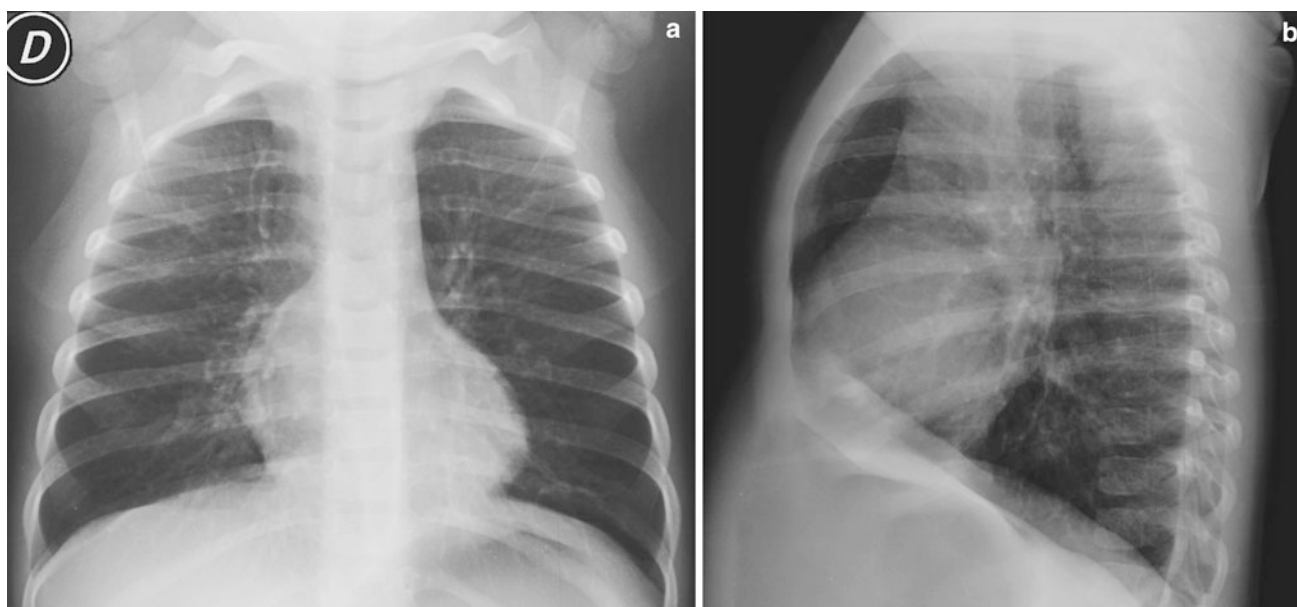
Frontal (a) and lateral (b) chest radiographs of a child with bronchiolitis. Note also flattening of the diaphragm and a retrosternal lucency in the lateral view
